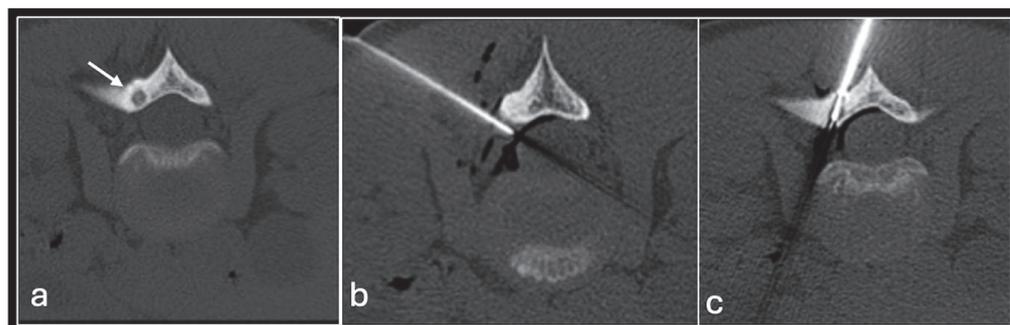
Axial CT showing osteoid osteoma of lumbar spine (arrow) (a) treated with radiofrequency ablation with neuroprotection using air (b,c).
